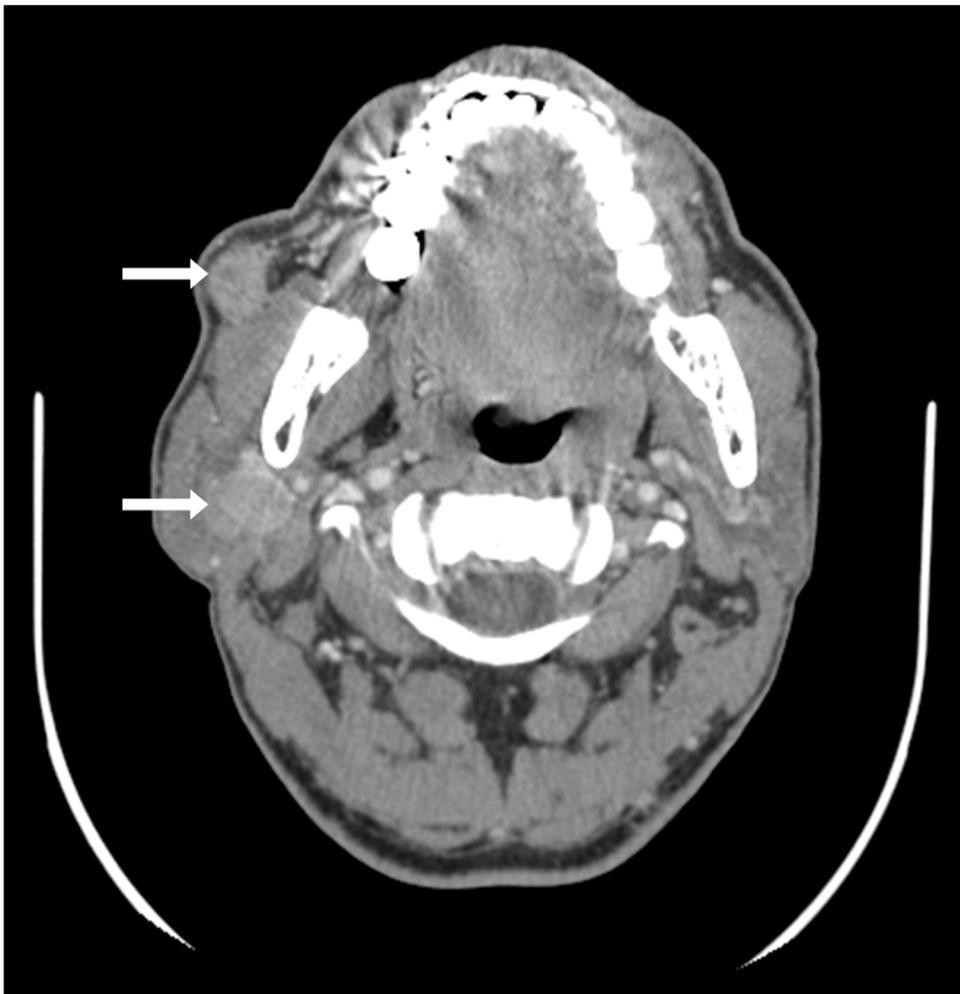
Typical preoperative magnetic resonance image showing the simultaneous occurrence of benign and malignant tumours in the ipsilateral parotid gland (arrows indicate the tumours).
